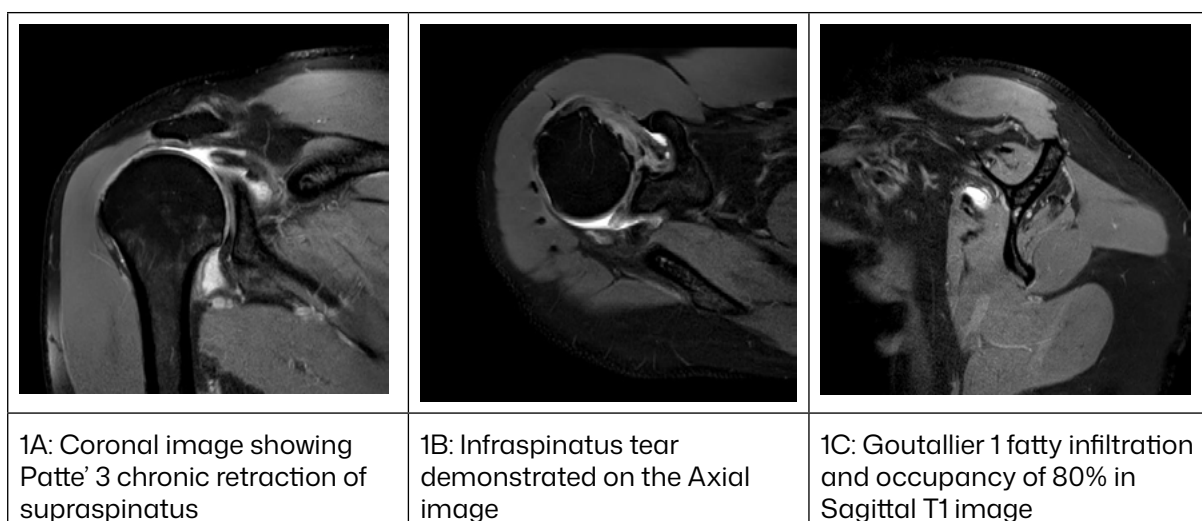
MRI images in the pre-operative period
